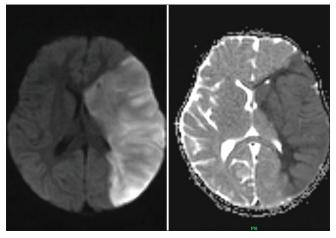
DWI and ADC images showing restricted diffusion in the left MCA territory
